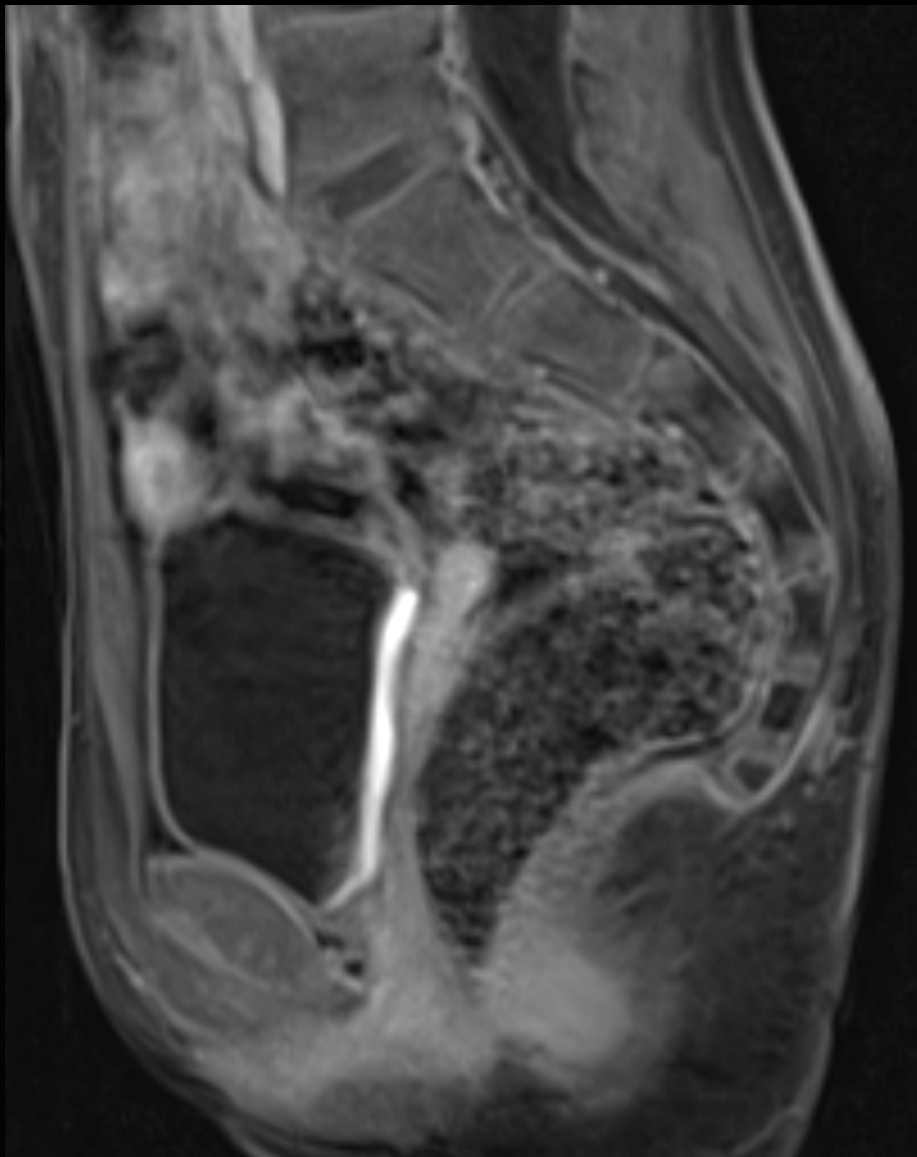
Post-surgical follow up MRI with sagittal T2W (A) and sagittal T1W VIBE FS CE (B) demonstrating no recurrent lesion in the surgical bed.
